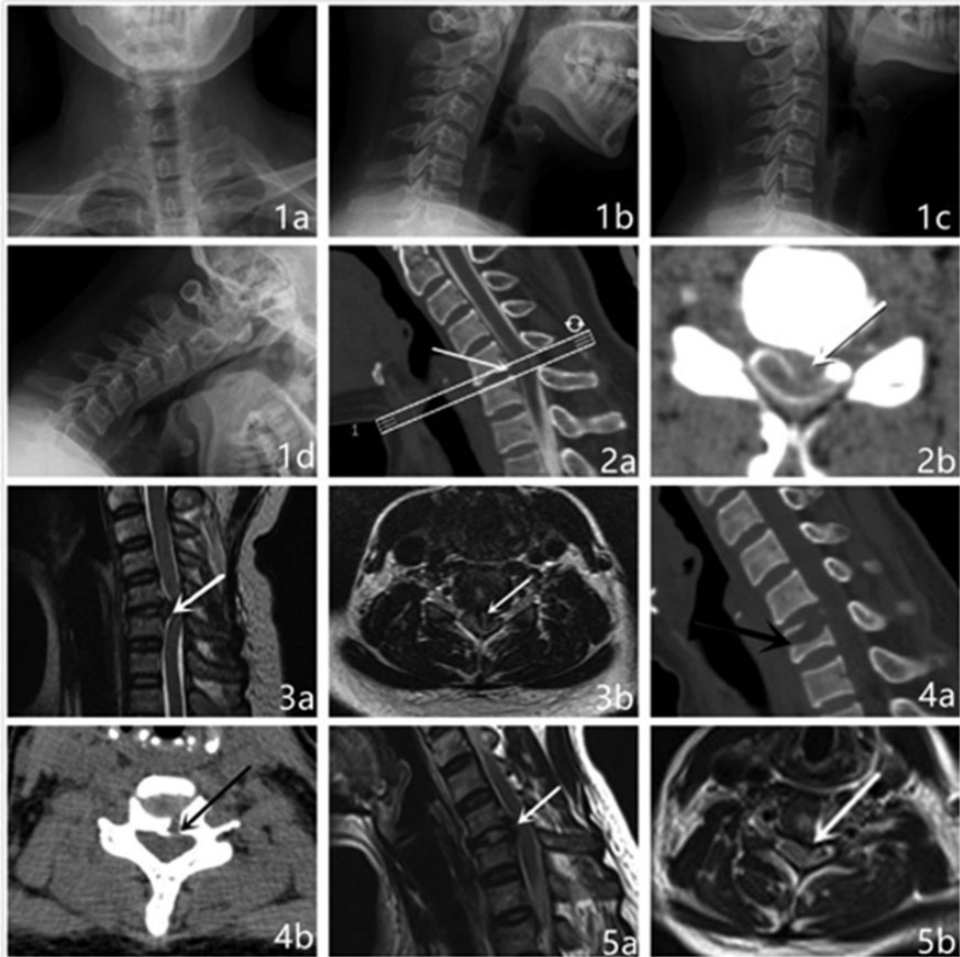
The white arrow indicates the herniated cervical disc, and the black arrow indicates the channel. (1a–d) Preoperative radiographs. (1a) Positive position. (1b) Lateral position. (1c) Hyperextension position. (1d) Hyperflexion position. (2a, b) Preoperative computed tomography images. (2a) Sagittal position. (2b) Cross section. (3a, b) Preoperative magnetic resonance images. (3a) Sagittal position. (3b) Cross section. (4a, b) Postoperative computed tomography images. (4a) Sagittal position. (4b) Cross section. (5a, b) Postoperative magnetic resonance images. (5a) Sagittal position. (5b) Cross section.
